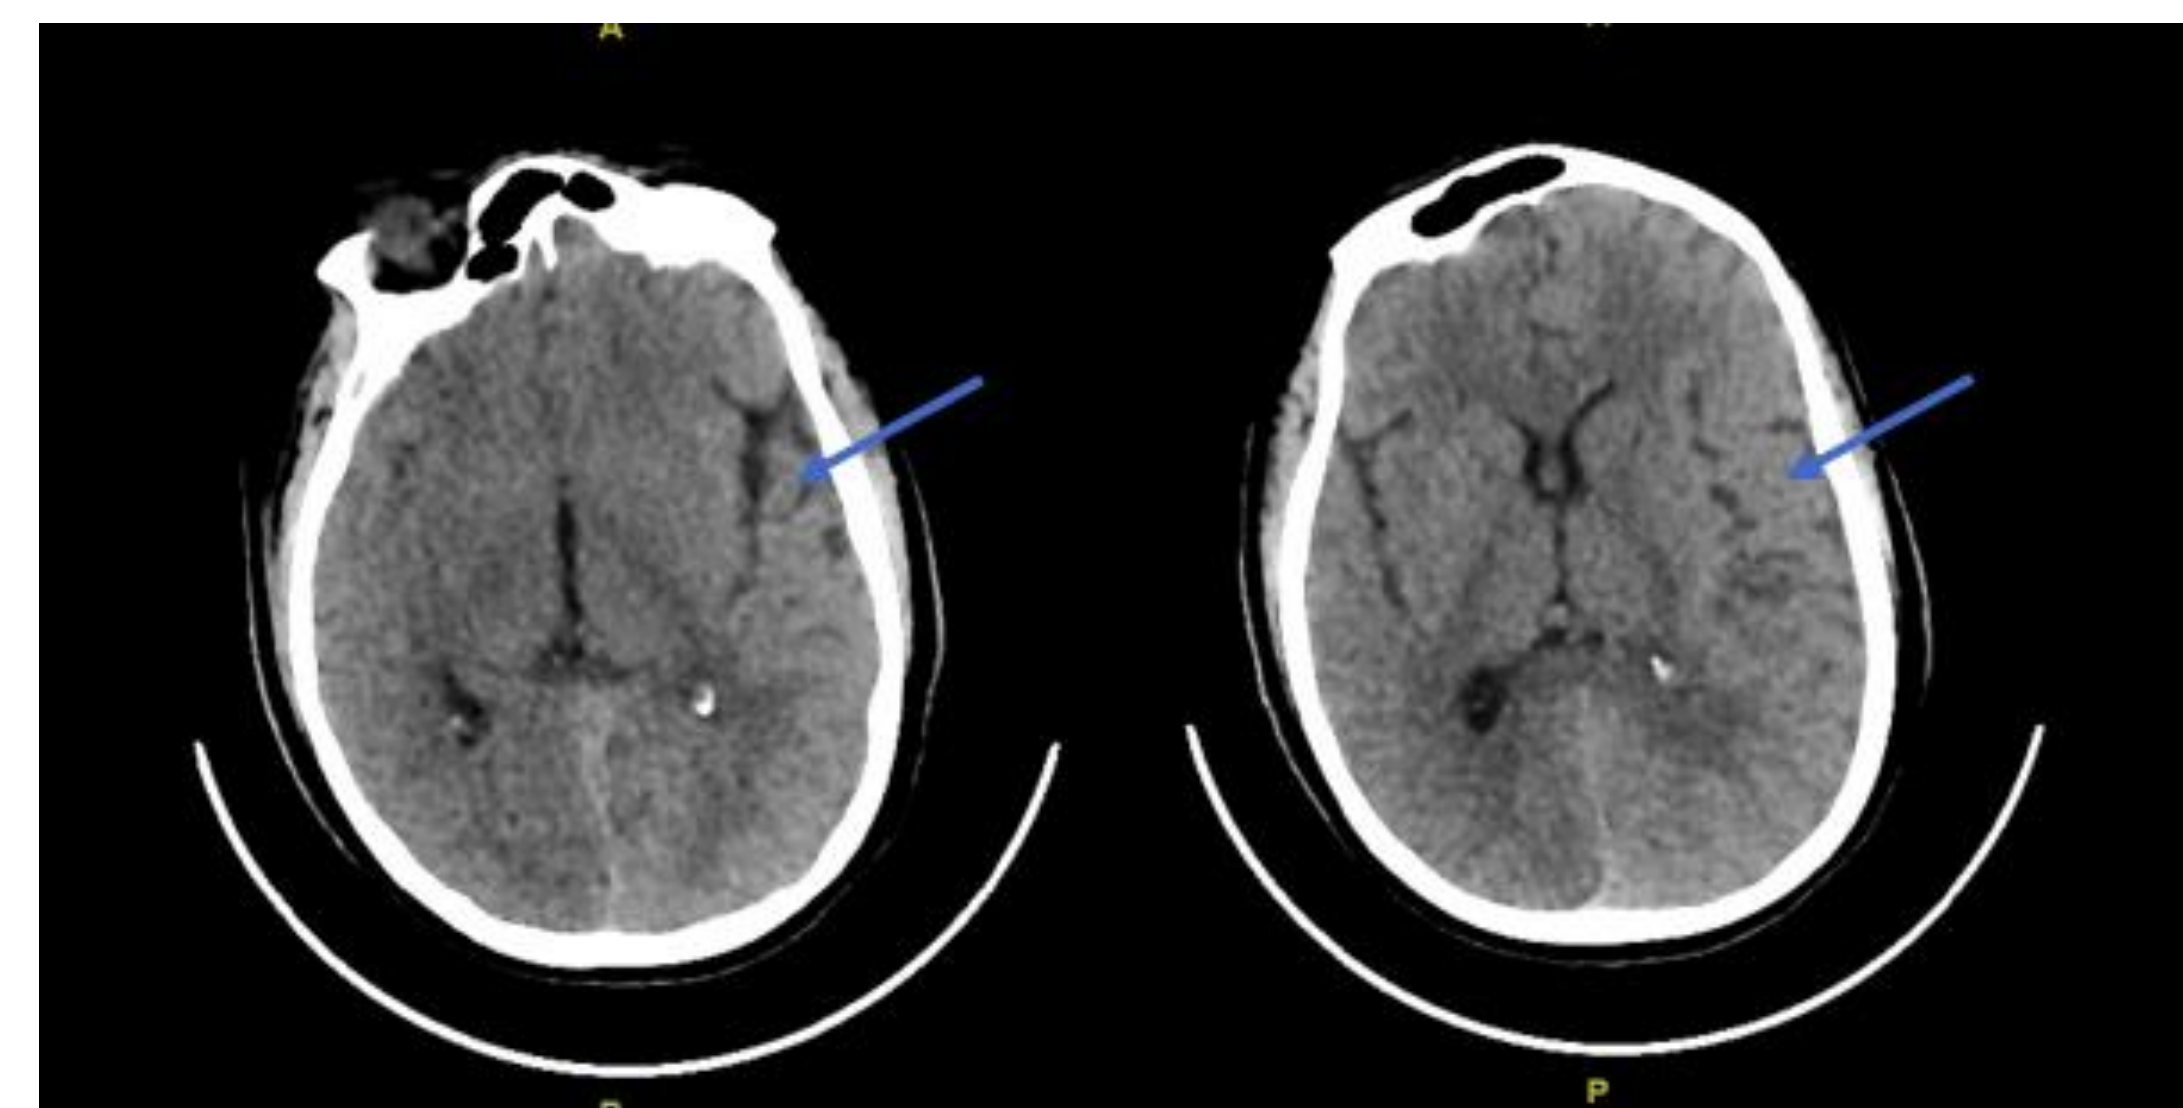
CT head. Left cerebral edema and cortical thickening.
